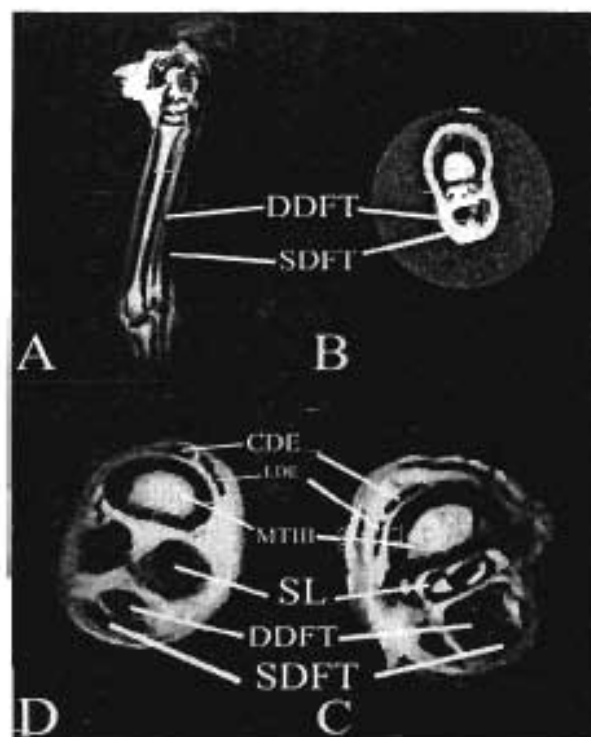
Normal MRI slice planes of sagittal (A) and transverse images of the metacarpal/metatarsal region showing the normal digital flexor tendons at the three divisions of the metatarsal region (B, C & D).
